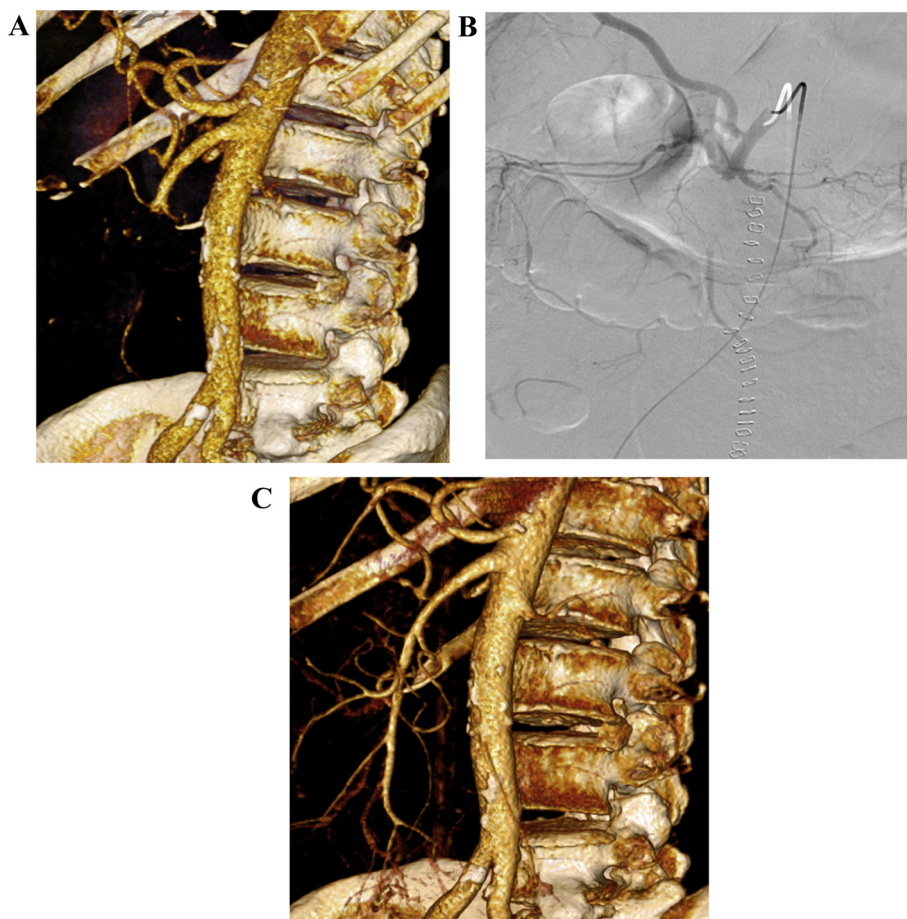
(A) Three-dimensional volume rendering of arterial phase computed tomography (CT) angiography showing a segmental thromboembolic occlusion of the SMA immediately distal to the right colic branch. (B) Selective catheterisation and angiography of the SMA occlusion. (C) Successful revascularisation of the SMA following catheter-directed thrombolysis, angioplasty and thromboaspiration.
